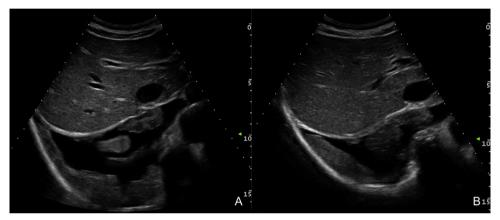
Abdomen Ultrasound (A and B) showed lobular and inhomogeneous masses in the right hemithorax with pleural effusion.
